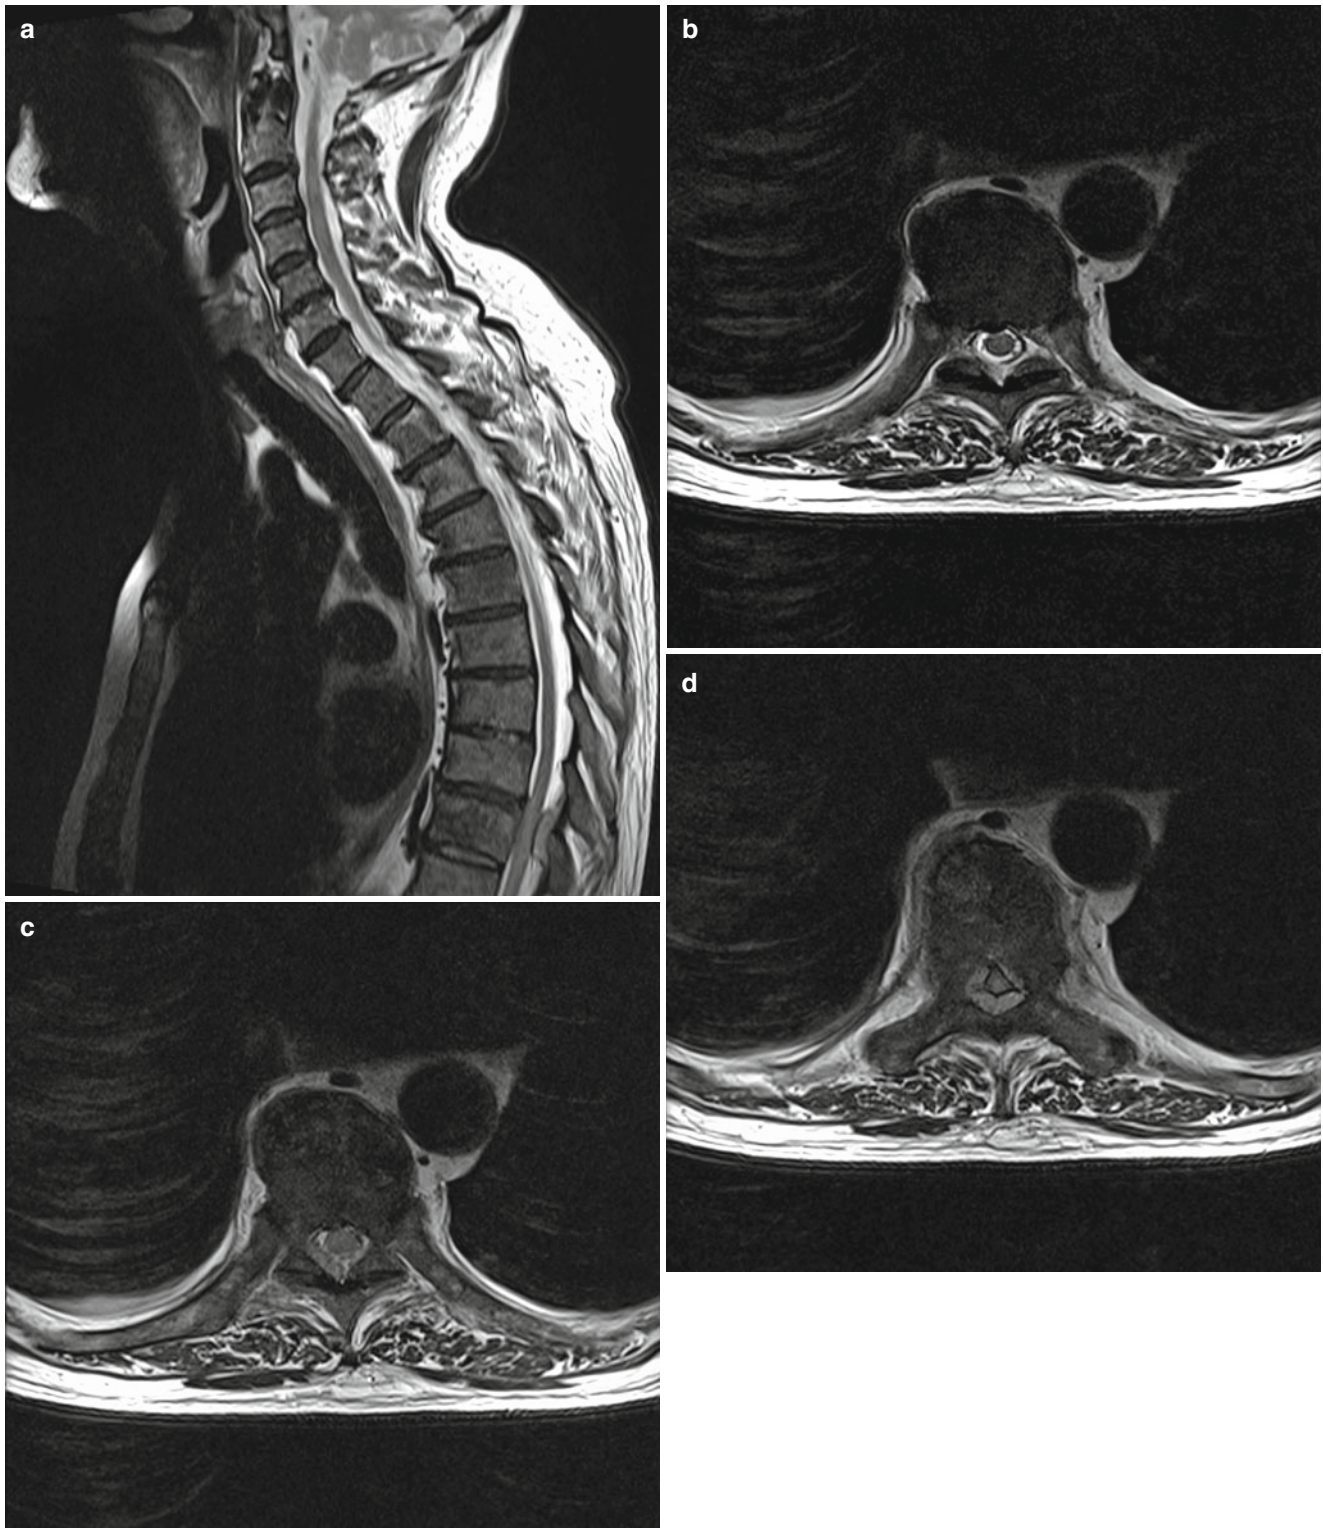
Spinal cord compression arising from vertebral metastasis. MRI sagittal and axial images of a lesion causing compression at the level of 9th thoracic vertebra. (a) Sagittal image showing spinal cord compression at T9. (b) Axial image showing normal CSF signal around the spinal cord at level of T8. (c) Axial image showing abnormal CSF
